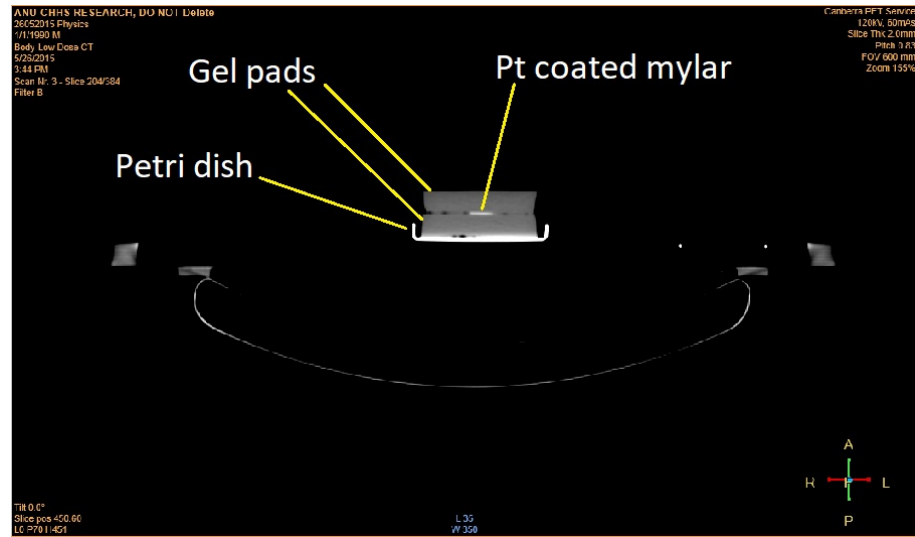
CT image of one sample on the PET bed. The change in density is evident where the platinum coated mylar is present. Also the gel pads and petri dish are visible.
